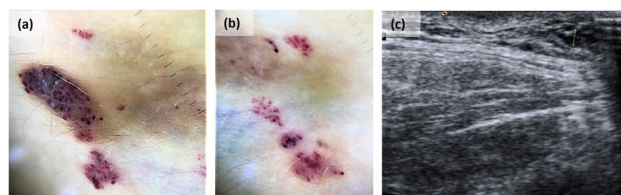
Dermoscopy and ultrasound images. (a) Dermoscopy of the dark reddish vesicles showed dark red/bluish lagoons. (b) Dermoscopy of the translucent vesicles showed light brown lacunas surrounded by paler septa, focal reddish areas, and hypopyon-like features. (c) Doppler ultrasound revealed a 3 mm slight thickening of subcutaneous tissue, composed of millimetric cystic structures without a Doppler signal inside consistent with a slow-flow vascular malformation.
